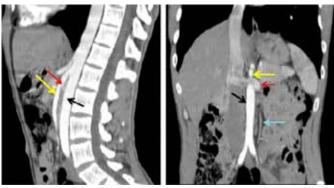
Computed tomography angiography showing nutcracker syndrome. Left renal vein (red arrow) is compressed between the aorta (black arrow) and the superior mesenteric artery (yellow arrow). Blue arrow showed the left spermatic vein thrombosis.
